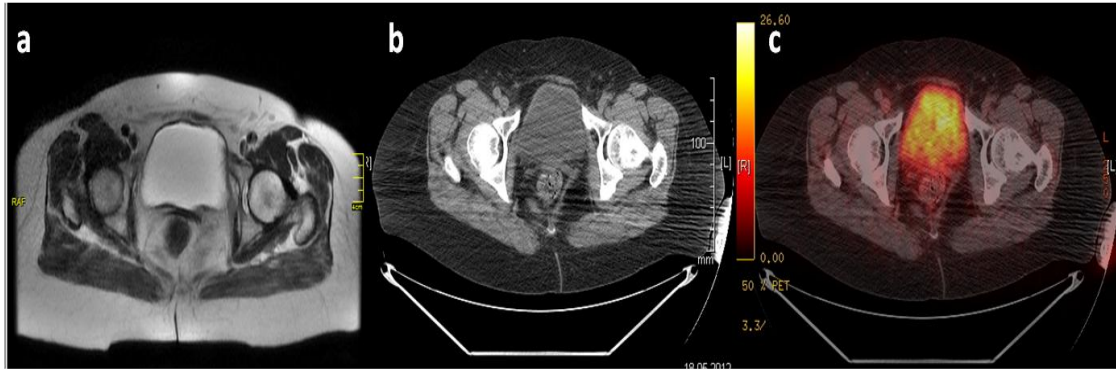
MRI (a), computerized tomography (b) and 18 FDG positron emission tomography (PET) (c) images showing no evidence of recurrent disease 5 years after operation.
